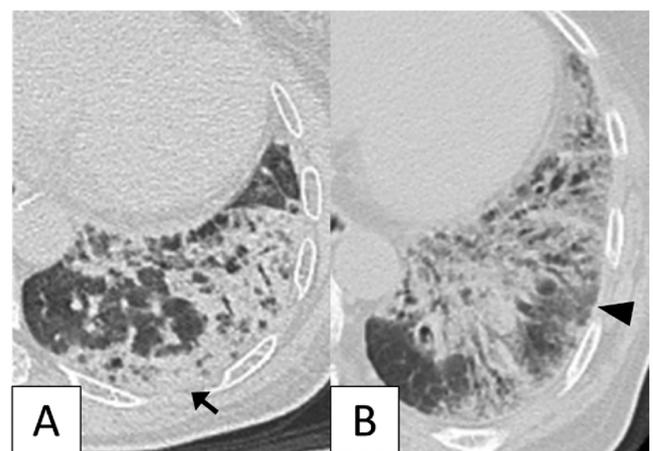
CT images at the level of the lung base in patients with mixed connective tissue disease-polymyositis/dermatomyositis pattern. A, CT image in a 68-year-old woman shows consolidation (arrow). B, CT image in a 54-year-old woman shows consolidation (arrow) and ground-glass opacity (arrowhead).
